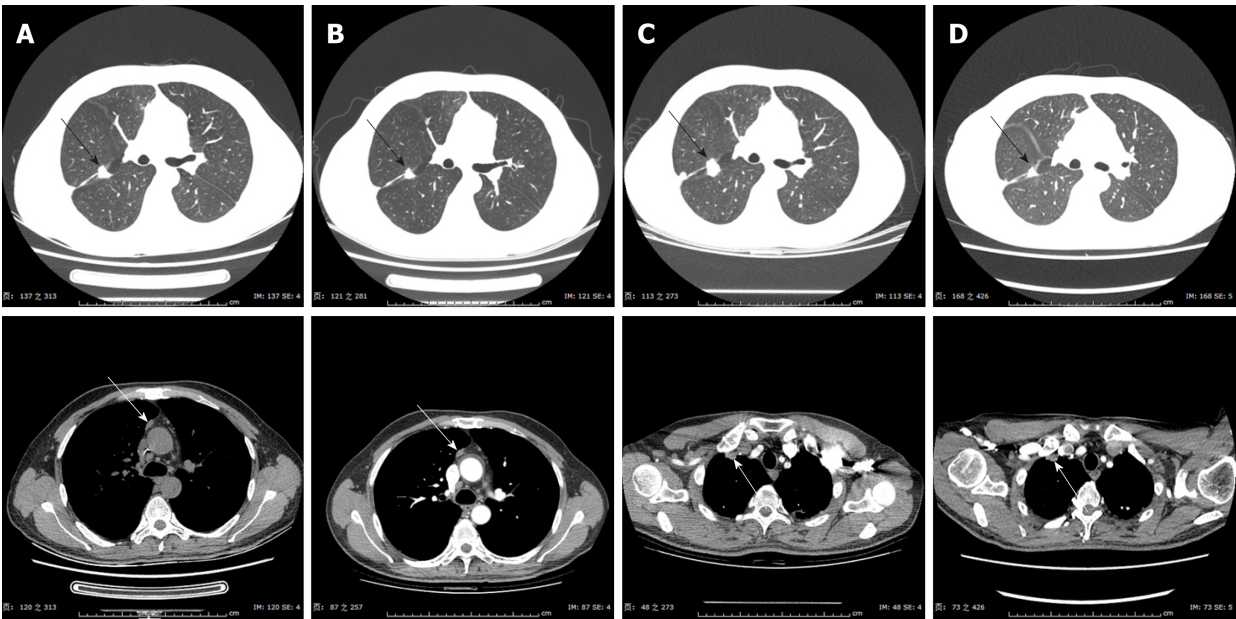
Images from computed tomography showing the tumor response up to the fourth-line therapy of NVB + Endo. A: Imaging performed on May 17, 2016, after seven cycles of nab-PC therapy; B: On December 26, 2016, the disease was classified as partial remission; C: On April 17, 2017, the disease was classified as progressive; D: On April 27, 2017, the tumor was found to have a response to radiation therapy in the right lung (DT = 50 Gy/5F). Nab-PC: Nab-paclitaxel; NVB + Endo: 25 mg/m² vinorelbine on days 1 and 8, and 30 mg endostar on days 1-7.
